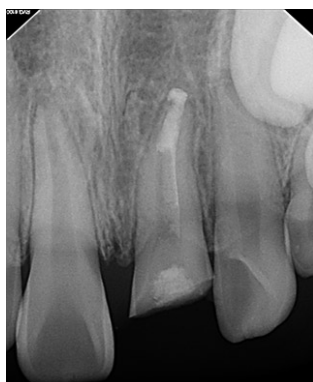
Periapical view after MTA apexification.
